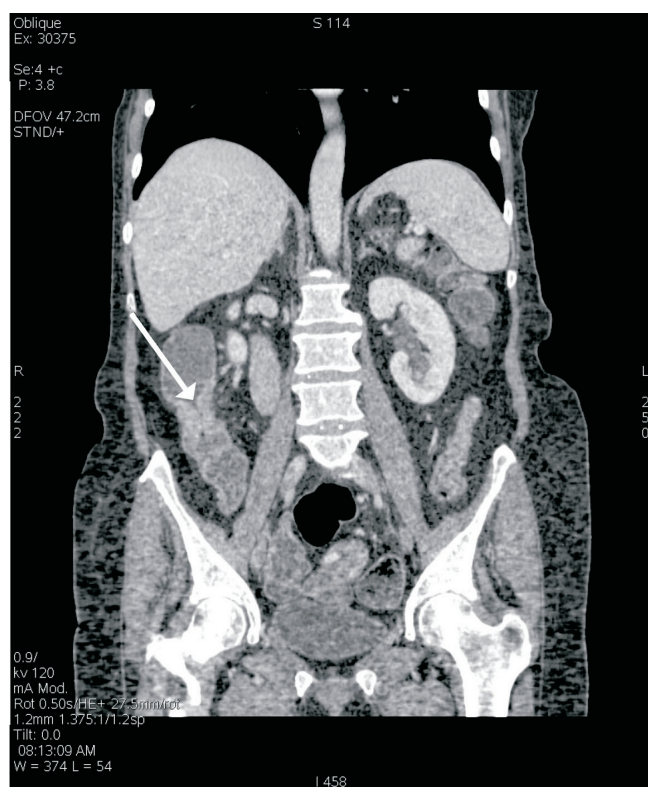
Abdominal CT scan with contrasting agent. Colon descendens distal area narrowing with bowel wall thickening up to 1.7 cm.
